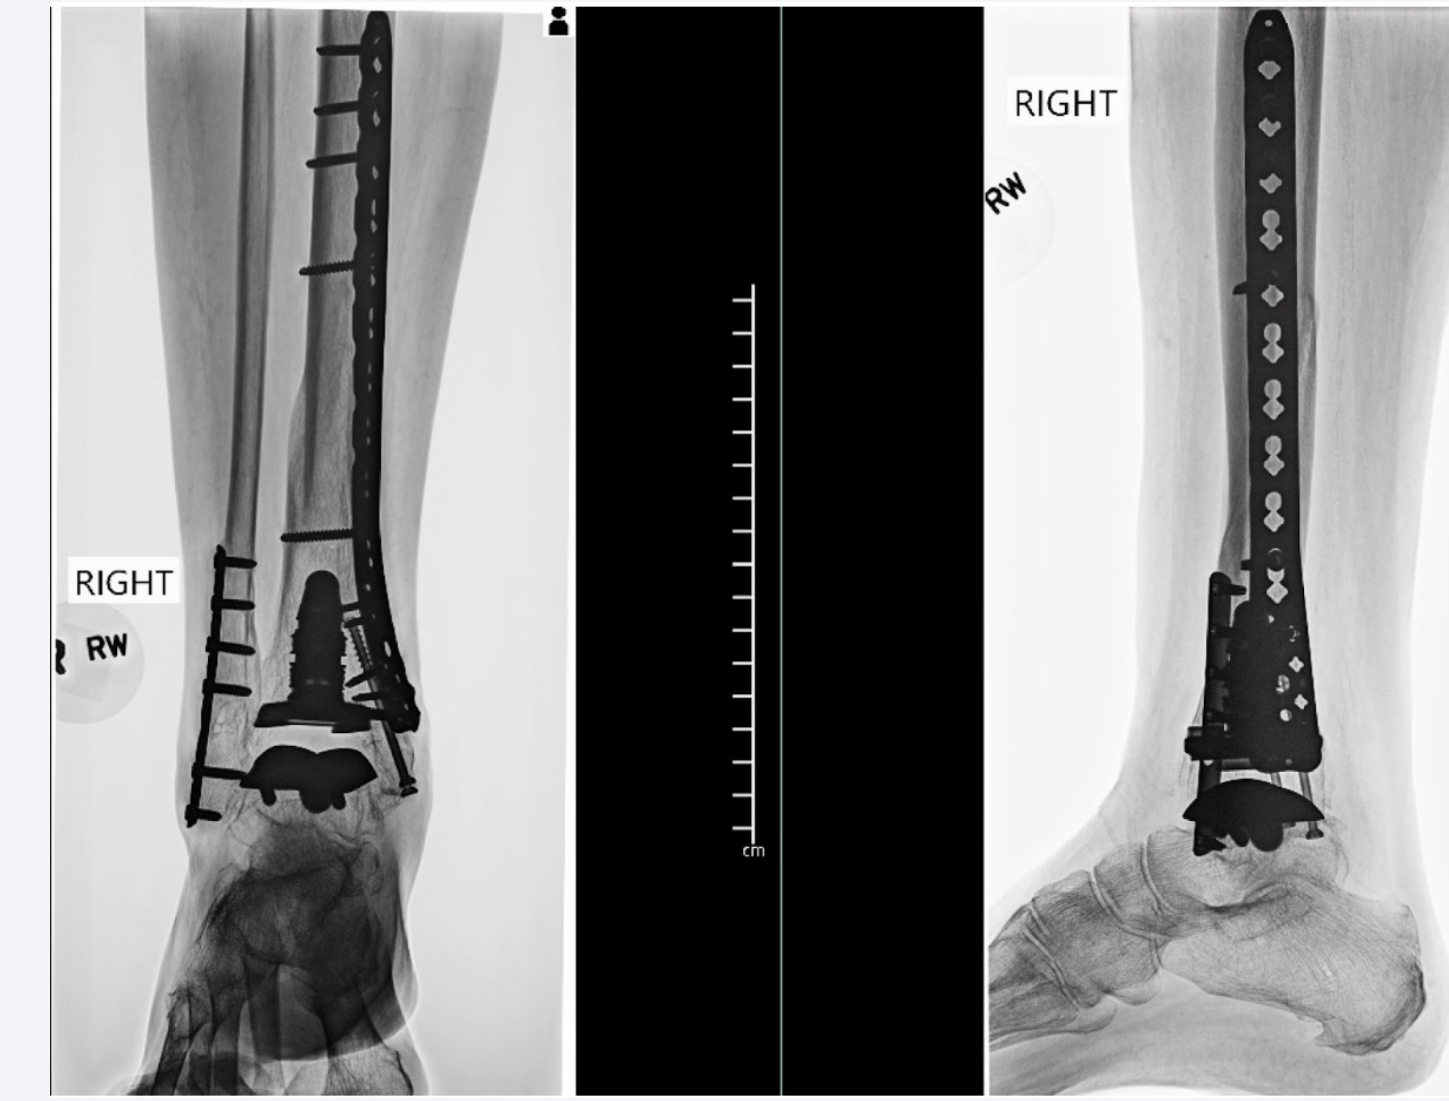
Patient 2 Anteroposterior (left) and lateral (right) radiographs of a 76-year-old female of Figure 3 at six months after stabilization with locking screw and plate technology with a hybrid combination of locking and nonlocking screws. Union of the fracture sites is noted with a stable implant.
